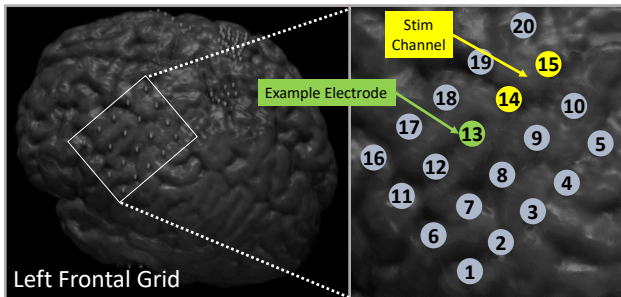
Left: MR-CT co-registered images showing the placement of the  $4 \times 5$  ECoG grid. Right: Stimulation channel is highlighted yellow and worst-case example electrode is highlighted green on the zoomed-in image.
